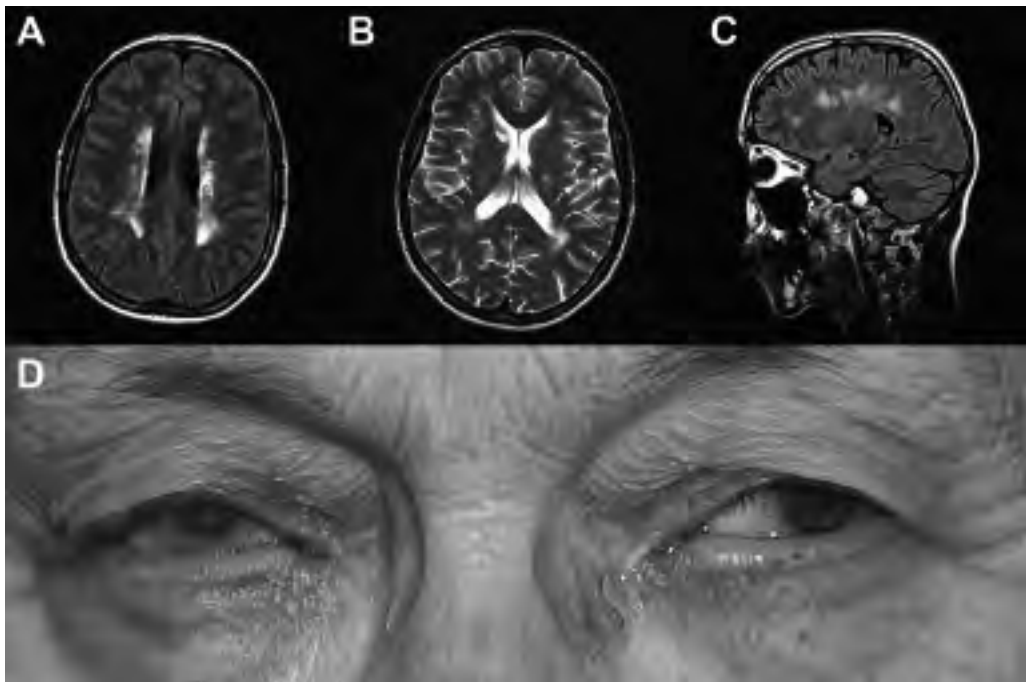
Brain MRI of the index patient (A,B,C). FLAIR (A,C) and T2- weighed (B) images show periventricular leukomalacia. Picture of ocular features of the mother (D), with microphthalmia and status after many ocular operations because of congenital cataract and secondary glaucoma.
